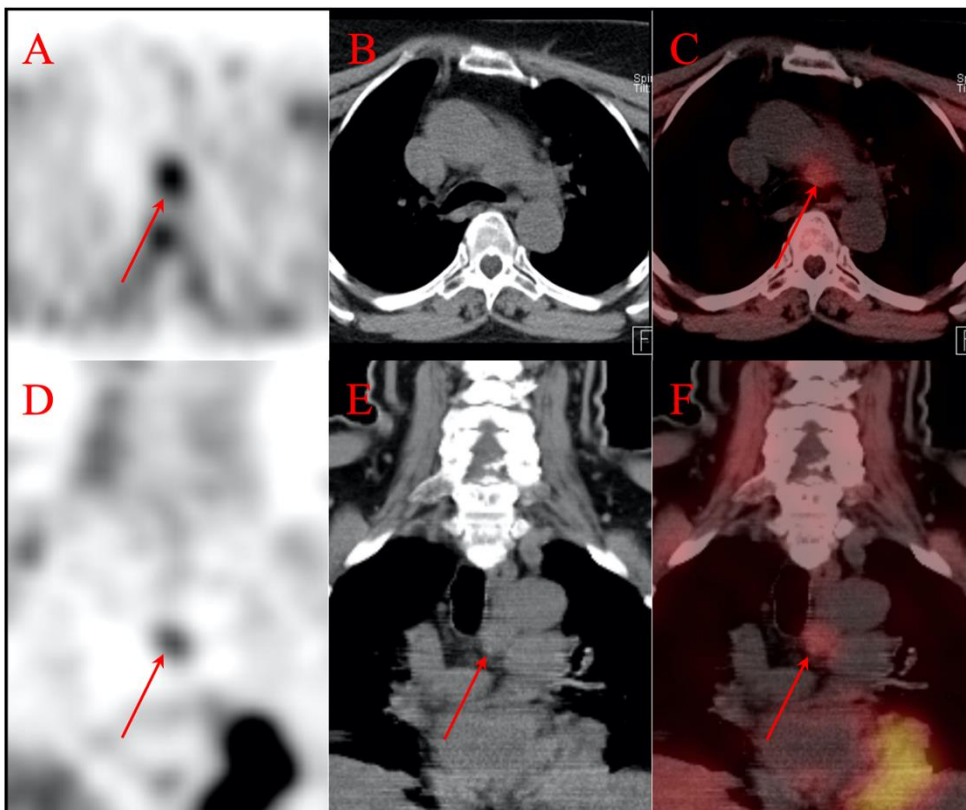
A mediastinal PTA (red arrow) with focal sestamibi uptake (A and D). Nonenhanced CT (B and E) does not contribute much to detection, but rather to elucidate the topographic anatomy.
